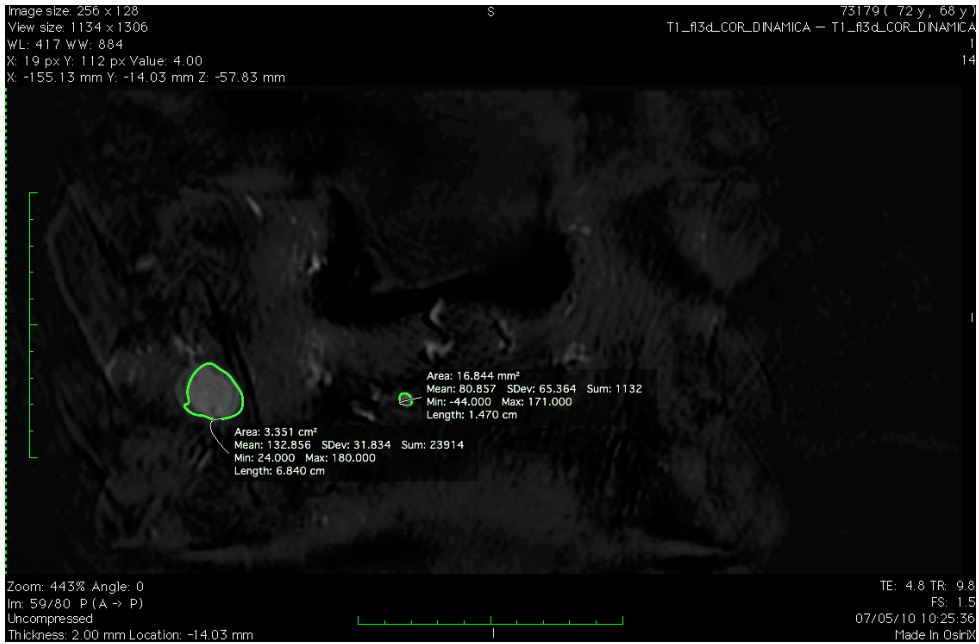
A DCE-MRI segmented slice. Two suspicious ROIs have been automatically detected by means of the CAD system.
